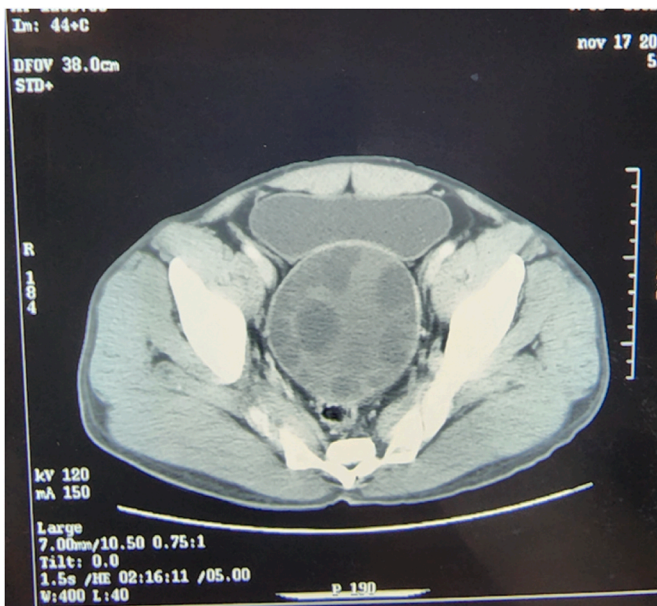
Computed tomography image of a type III retrovesical hydatid cyst causing compression of the bladder.
